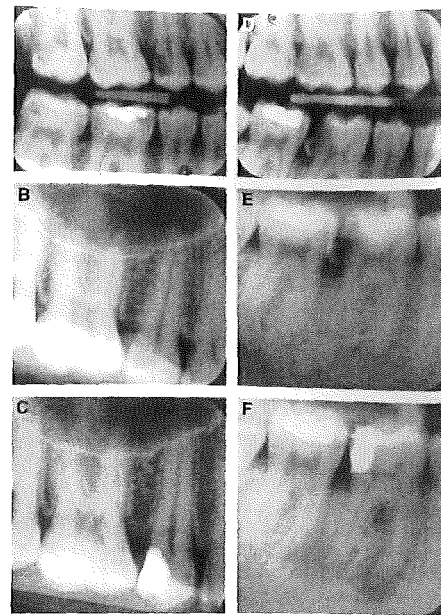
A, B: Preoperative radiographs of a permanent upper right second premolar (stepwise excavation). At the 1-yr radiographical follow-up (C) the tooth was classified as a success (pulp vitality without apical radiolucency). D, E: Preoperative radiographs of a permanent lower right first molar (direct complete excavation). At the 1-yr follow-up (F) the tooth was classified as a failure (no pulp vitality with apical radiolucency).
